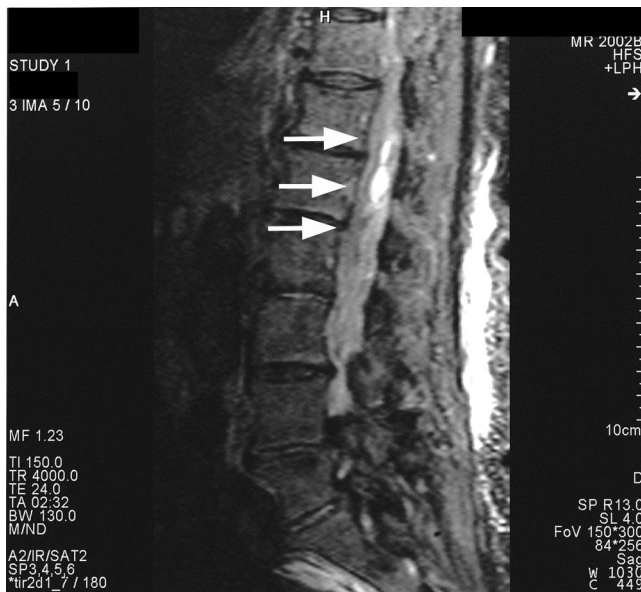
T2 sagittal magnetic resonance image showing the large extension of the hematoma (arrows), as well as its heterogeneity.
